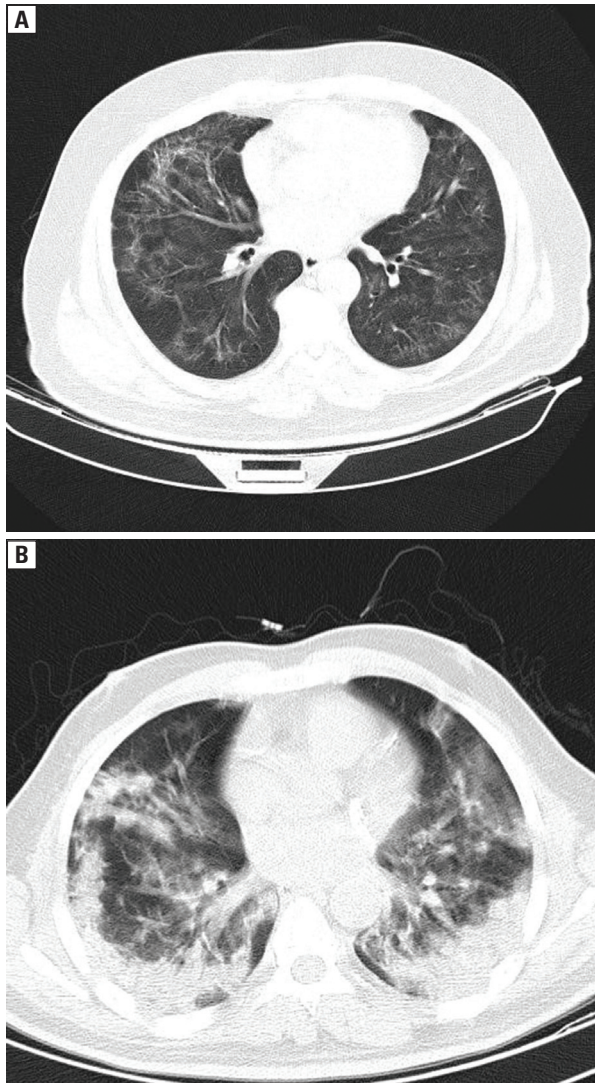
A. Subpleural band-like consolidation in the lung base of a 54-year-old man presenting with acute onset of respiratory symptoms. B. Follow-up CT scan performed 50 days later showed ground-glass opacification and innumerable small linear opacities that, by summation, resembled a net-like reticulation pattern appearance
